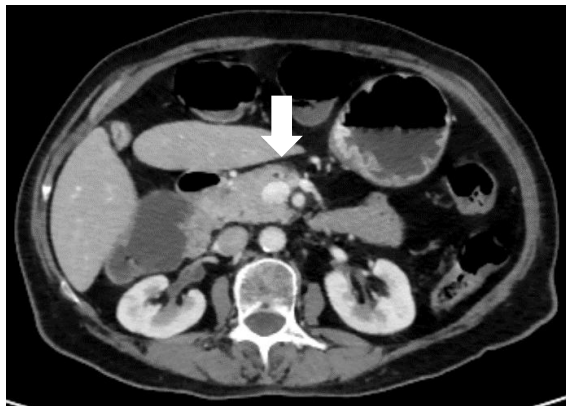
CT enteroclysis axial slice
